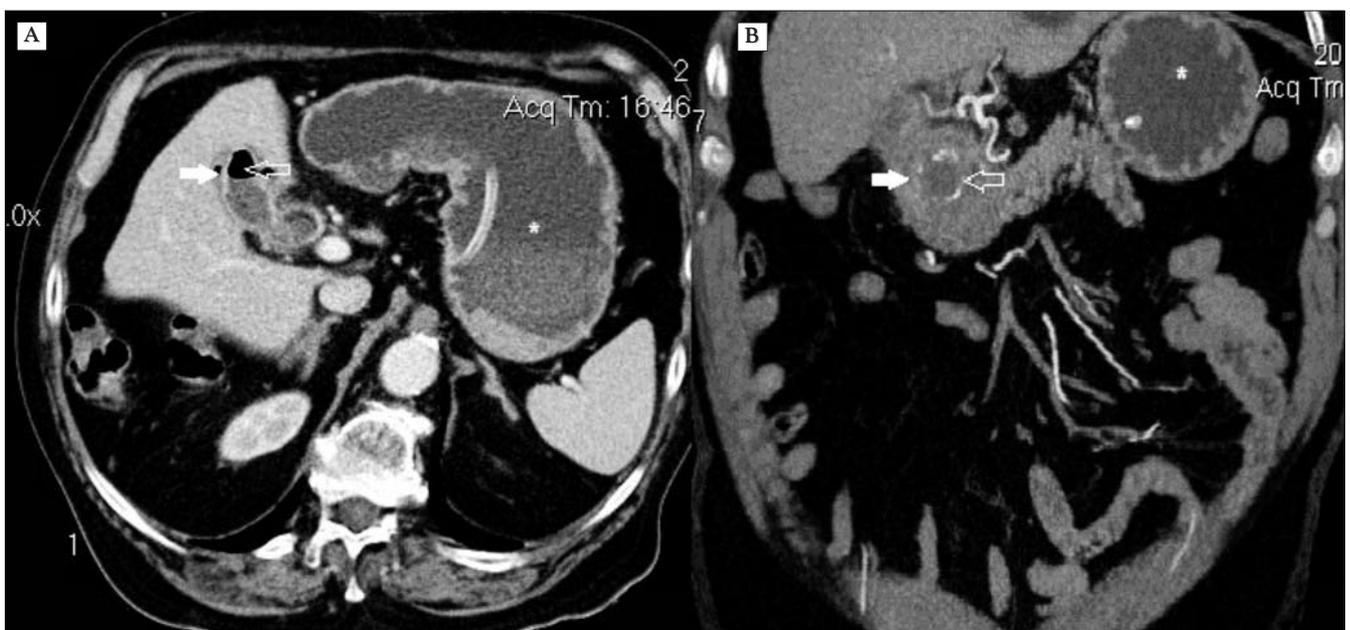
Abdominal computed tomography showing (A) the presence of gas in the gallbladder wall (filled white arrow) and pneumobilia (open white arrow); (B) a large gallstone in the duodenum (open white arrow) with secondary dilated stomach (white asterisk) and an air-filled fistula that extends from the gallbladder fosa to the first part of the duodenum (filled white arrow).
